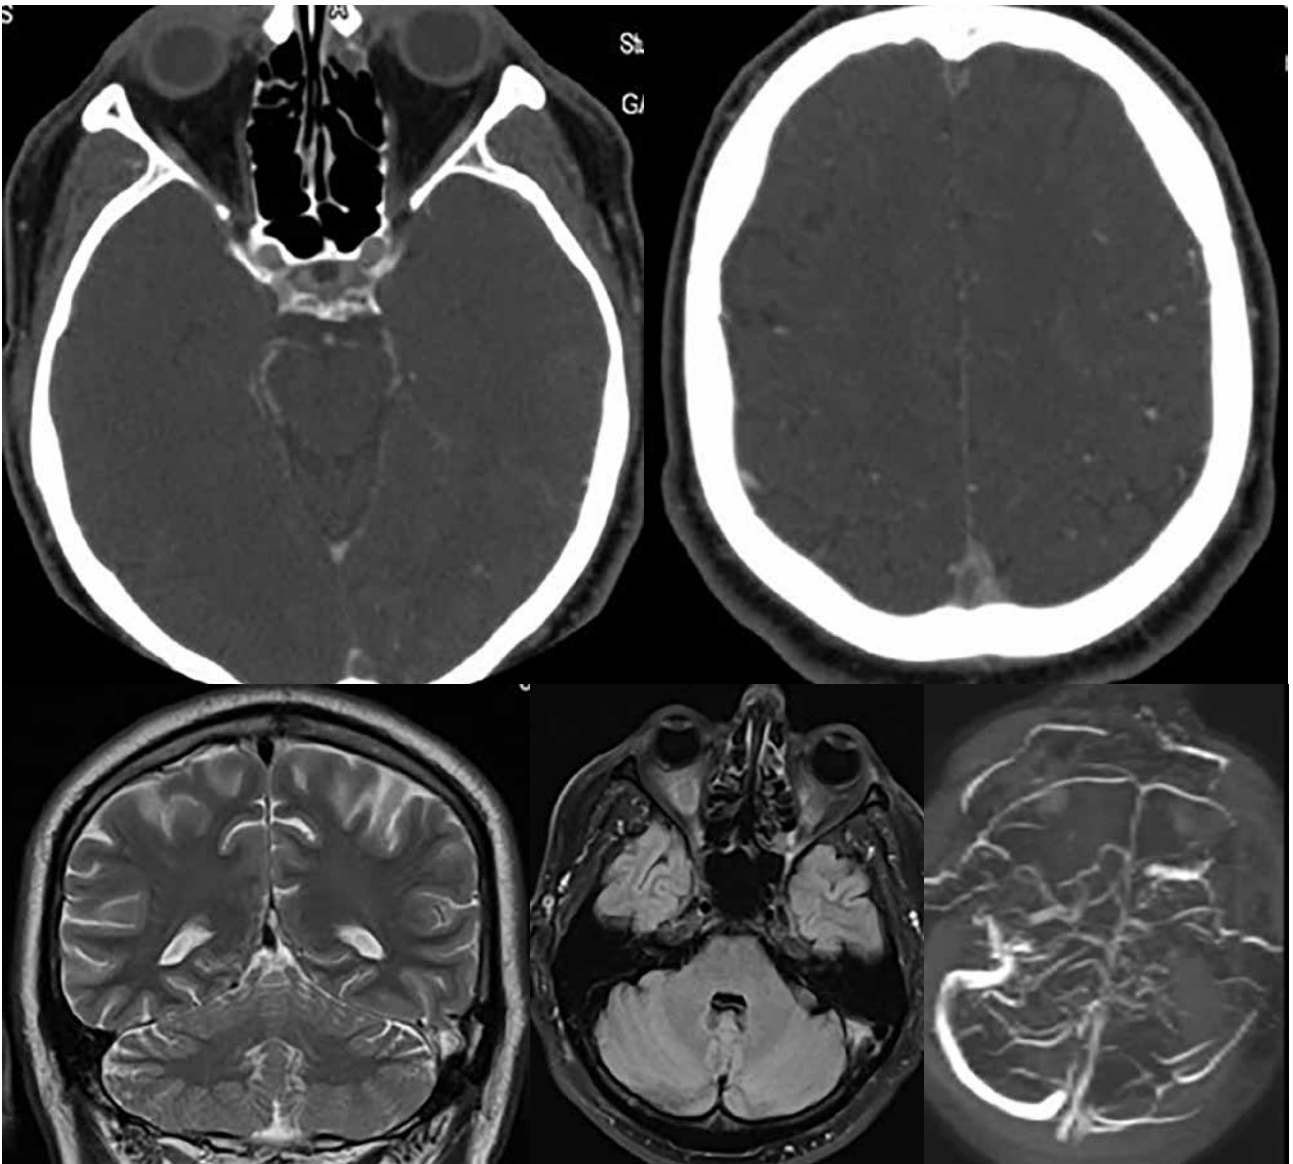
Multiple different venous sinus thromboses (thrombosis of the superior sagittal sinus: a, b - axial CT; and thrombosis of the left transversal sinus vein MRI: c - T2W coronal; d - T2W FLAIR axial; e - TOF).
